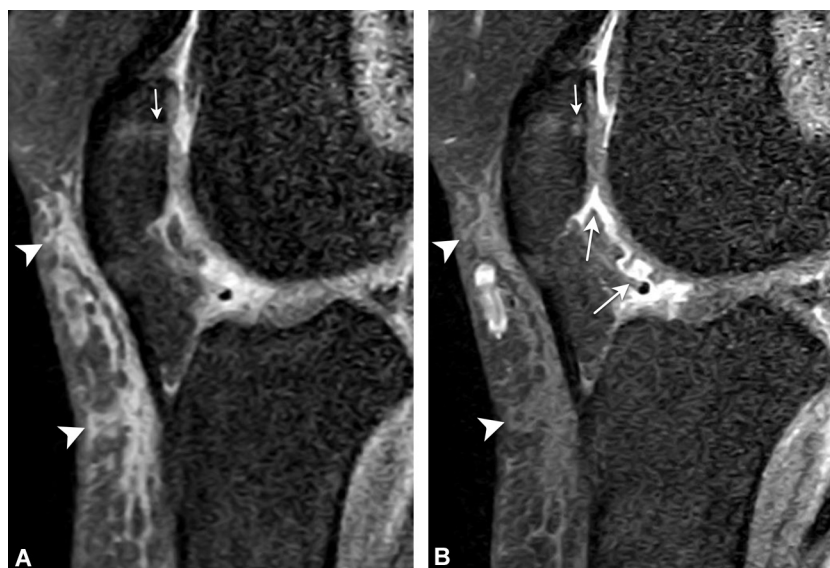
A 71-year-old and overweighted (130 kg) woman without anterior knee pain. A. Fat-suppressed PD-weighted MR image in the sagittal plane shows moderate anterior edema (arrowheads). B. No enhancement on post-contrast fat-suppressed T1-weighted image is visible in this region. Note the subchondral changes of patellar chondropathy (small arrows, A and B), and enhancement of synovial surfaces consistent with synovitis (large arrows, B).
